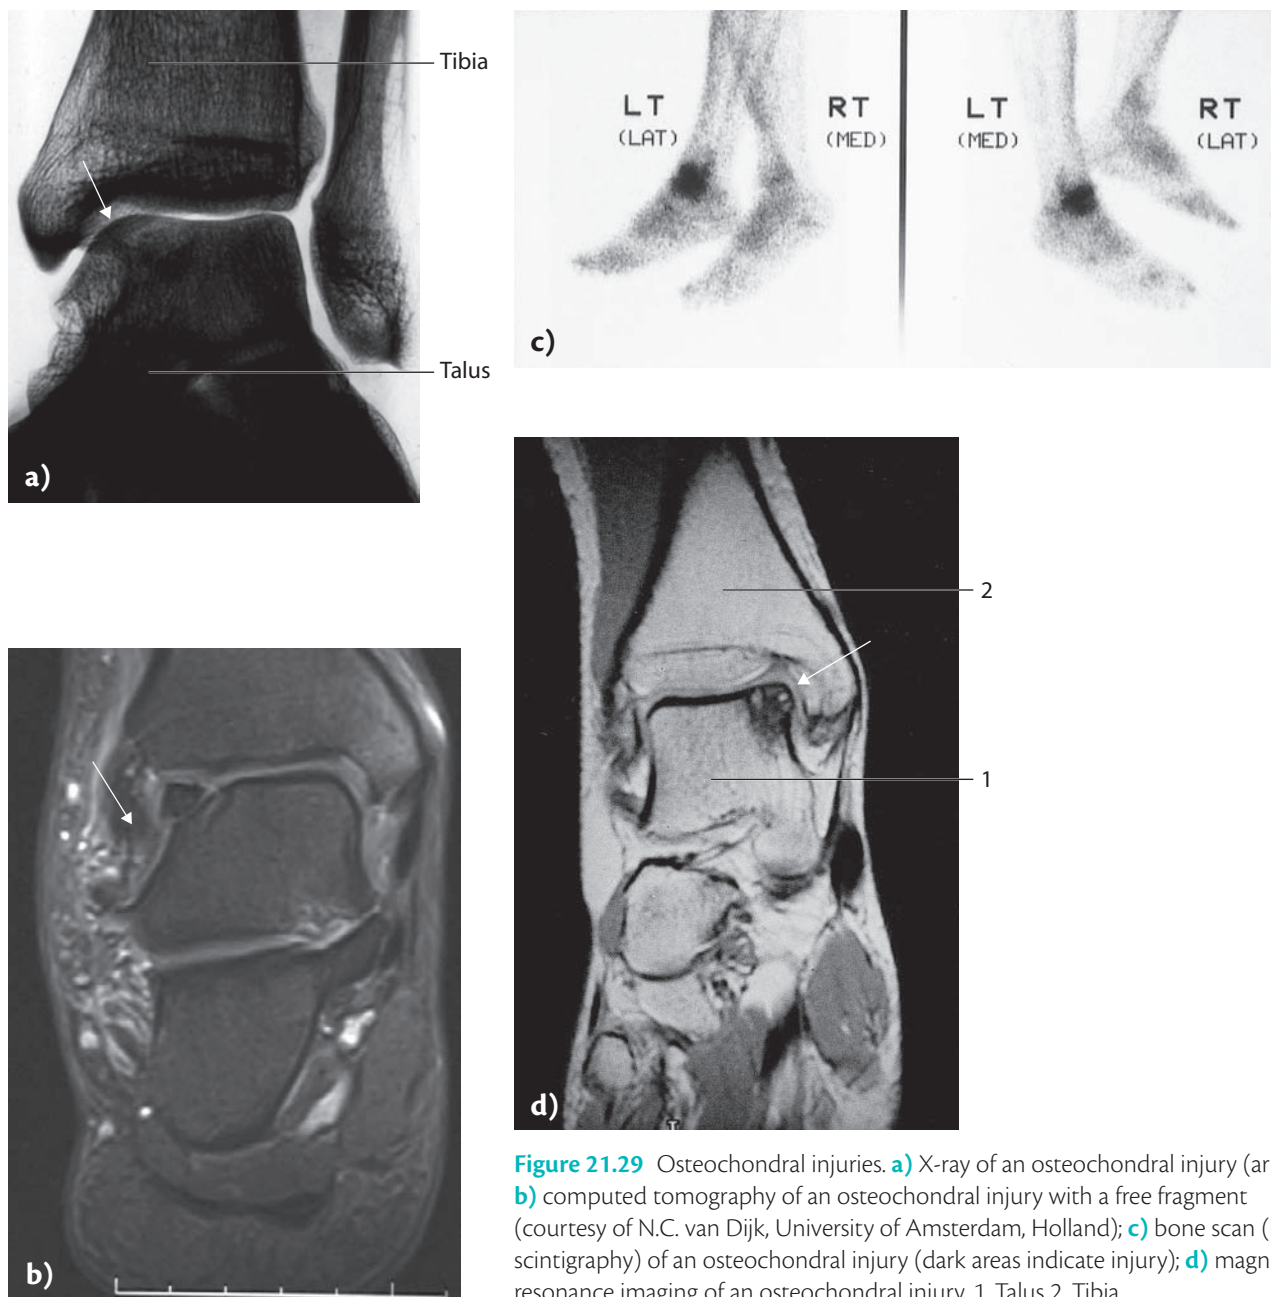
Osteochondral injuries. a) X-ray of an osteochondral injury (arrow); b) computed tomography of an osteochondral injury with a free fragment (courtesy of N.C. van Dijk, University of Amsterdam, Holland); c) bone scan (bone scintigraphy) of an osteochondral injury (dark areas indicate injury); d) magnetic resonance imaging of an osteochondral injury. 1. Talus 2. Tibia.
